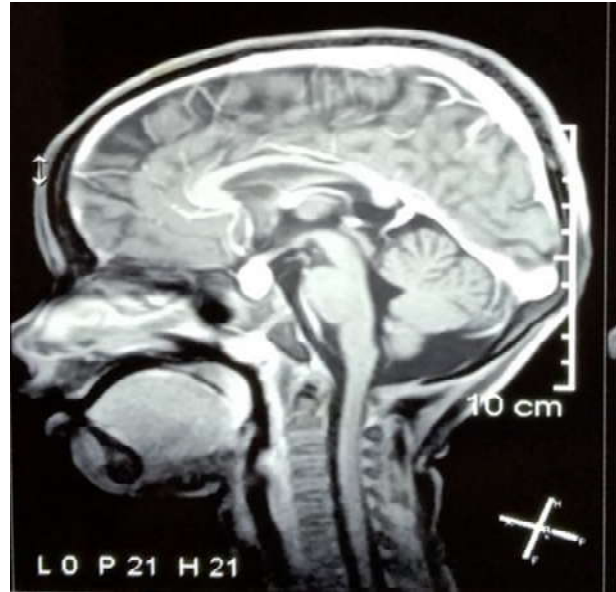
MRI Brain contrast sagittal and coronal view showed enlarged anterior pituitary gland showing intense enhancement on contrast.
